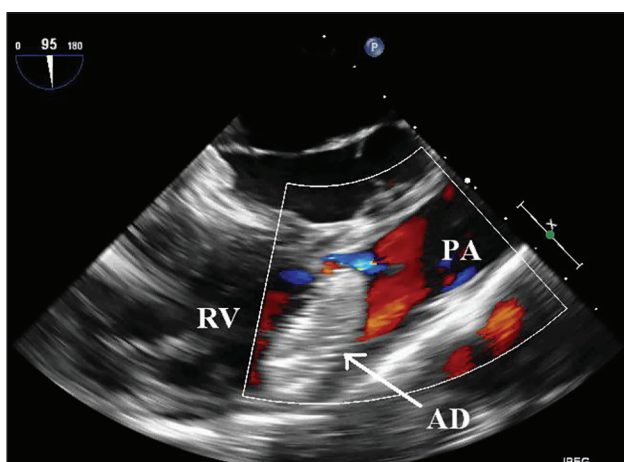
Transesophageal echocardiography two-dimensional color Doppler mid esophageal modified right ventricle inflow outflow view showing atrial septal defect device (indicated by white arrow) at right ventricular outflow tract and obstructing pulmonary artery flow. AD: Amplatzer device; RV: Right ventricle
